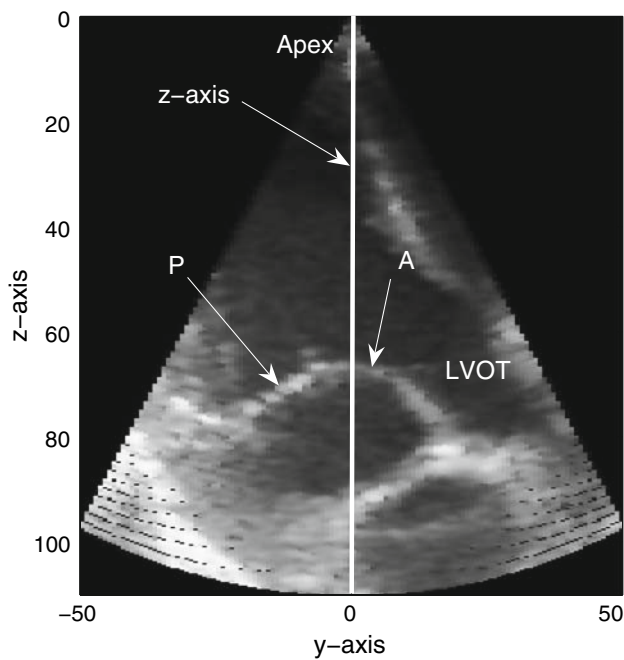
View of a plane of the 3D ultrasound recording. Anterior (A) and posterior (P) mitral valve leaflets and Left ventricular outflow tract (LVOT)
